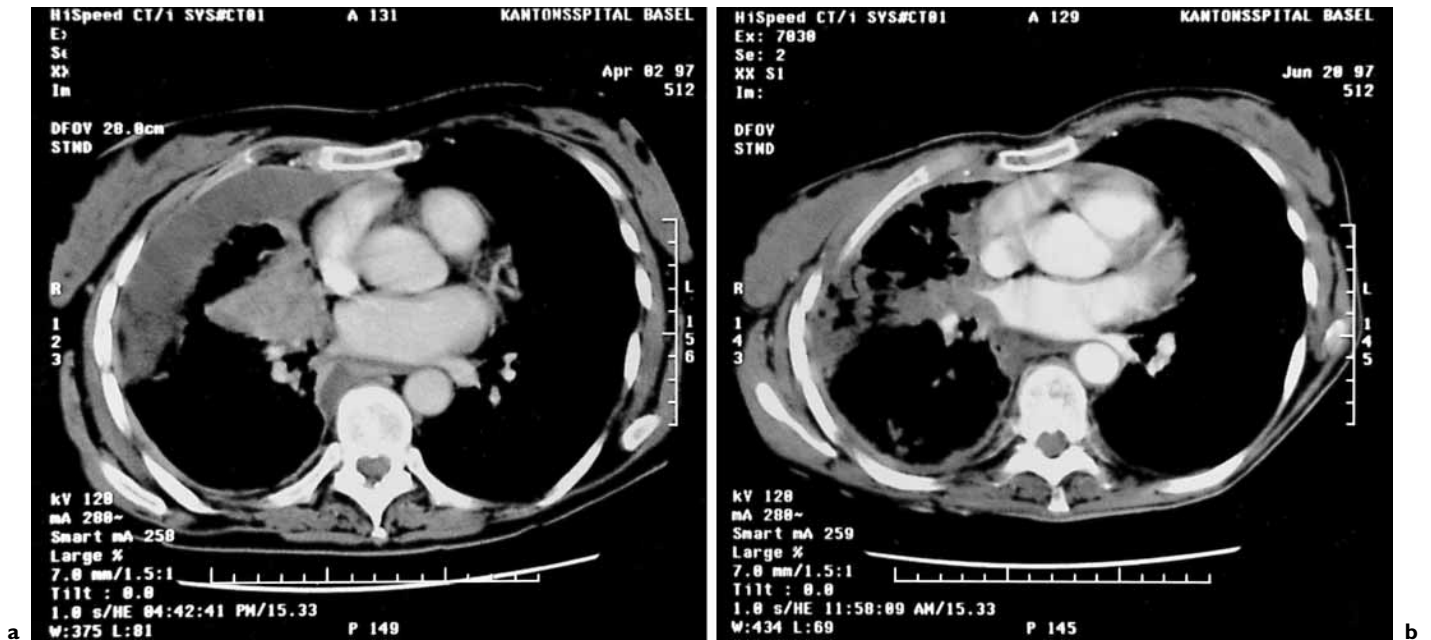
CT scans of a patient treated with 10^9 PFU of adenovirus-p53 before (a) and 2 months after (b) therapy. The reduction of the size of the injected lesion fulfills the criteria for a partial remission. The decrease of the volume of pleural effusion is due to a pleurodesis performed directly before gene therapy (courtesy of G. Bongartz, Division of Radiology, Kantonsspital, Basel).
